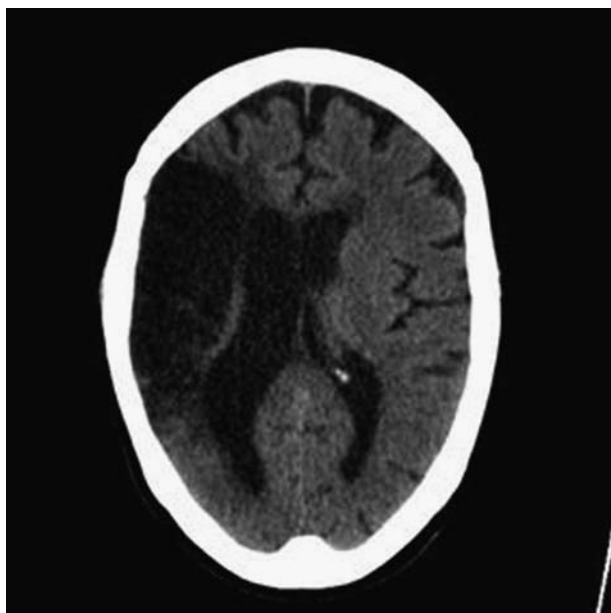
Follow-up MRI showing right-sided encephalomalacia.
